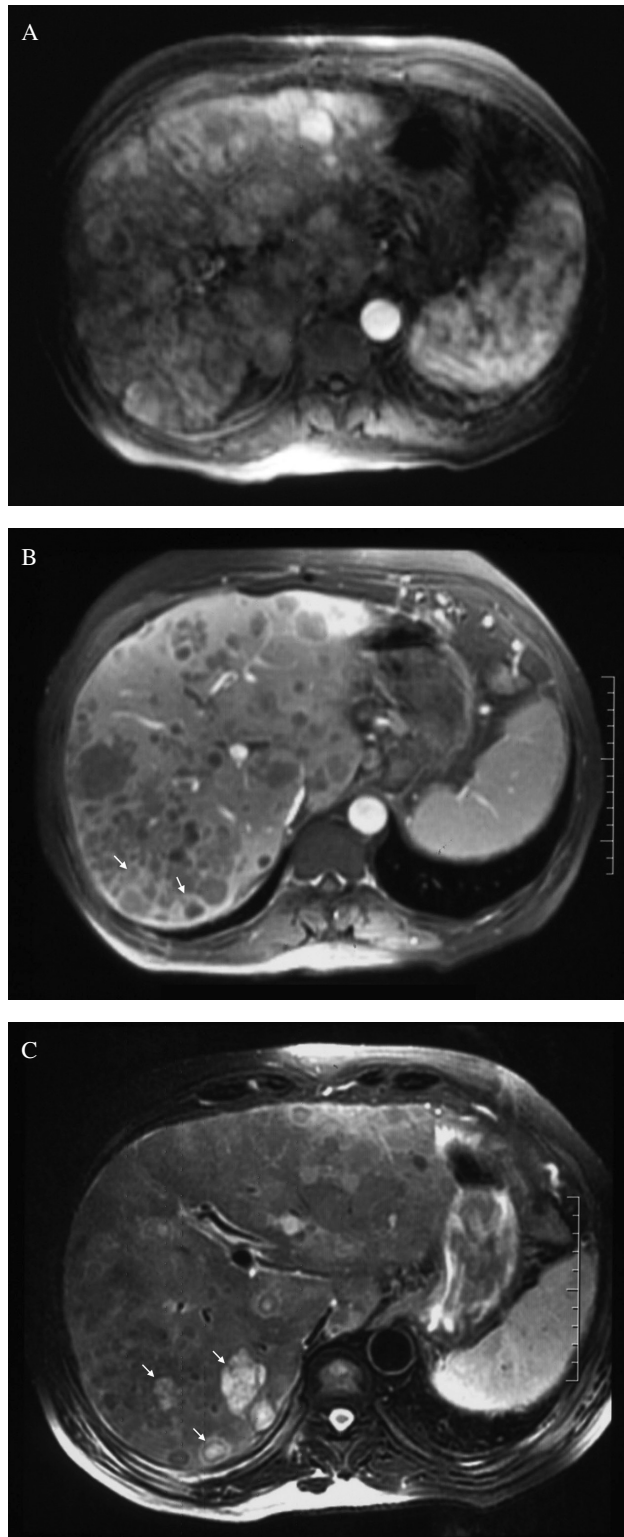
A 56-year-old male with diffuse-type HCC involving the entire liver. The serum alpha-fetoprotein level was 49 ng/ml. Post-contrast early-phase axial MR image (A) shows the tumor as areas of moth-eaten enhancement. On post-contrast late-phase axial MR image, there are irregular areas of washout, and also note the septae (arrows). The fat-suppressed T2-weighted axial MR image (C) just above the levels on A and B demonstrates areas of necrosis (arrows).
